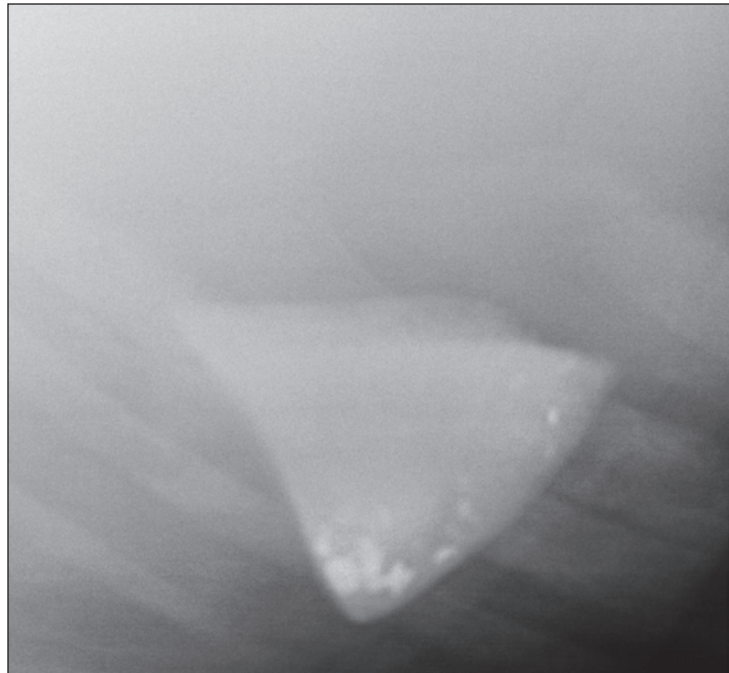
Right to left cranioventral radiographic view of the abdomen of a Thoroughbred mare evaluated because of mild to moderate signs of colic of 24 hours' duration.
